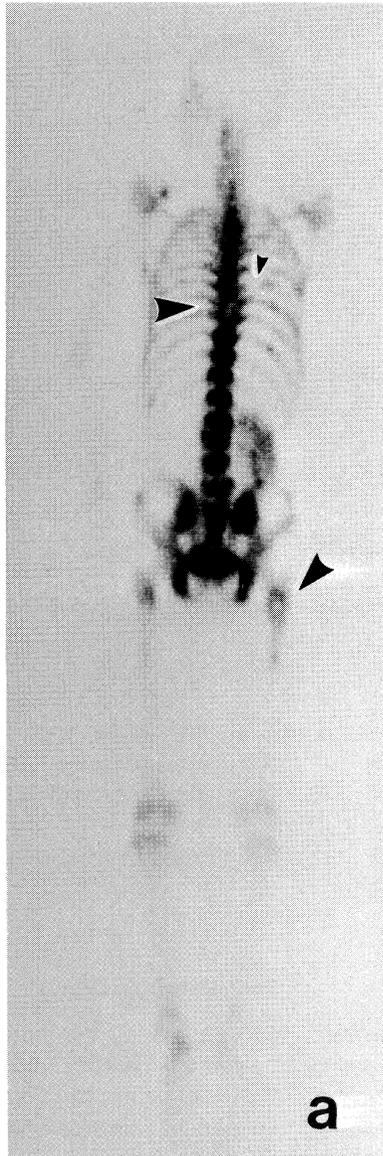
Bone scintigraphy showed photon deficient areas in the eighth thoracic vertebra, rib and right femur.
